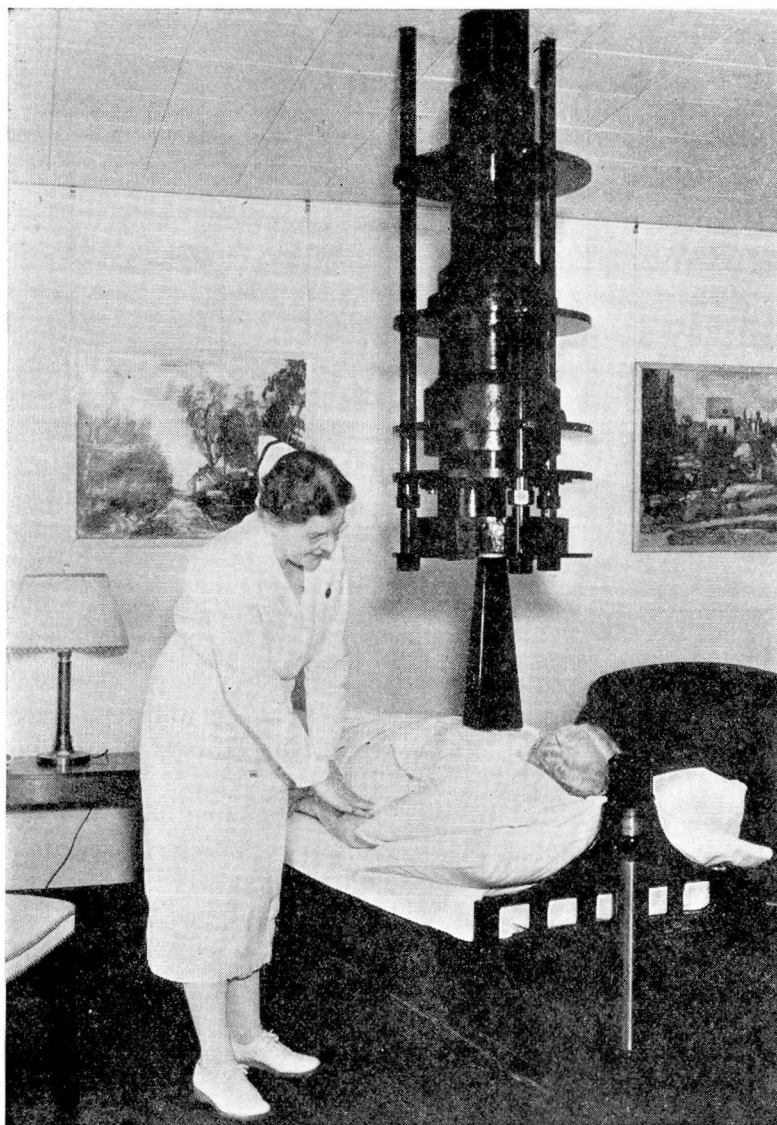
Lower end of 1200 KV roentgen ray tube (see fig. 4) in treatment room.
